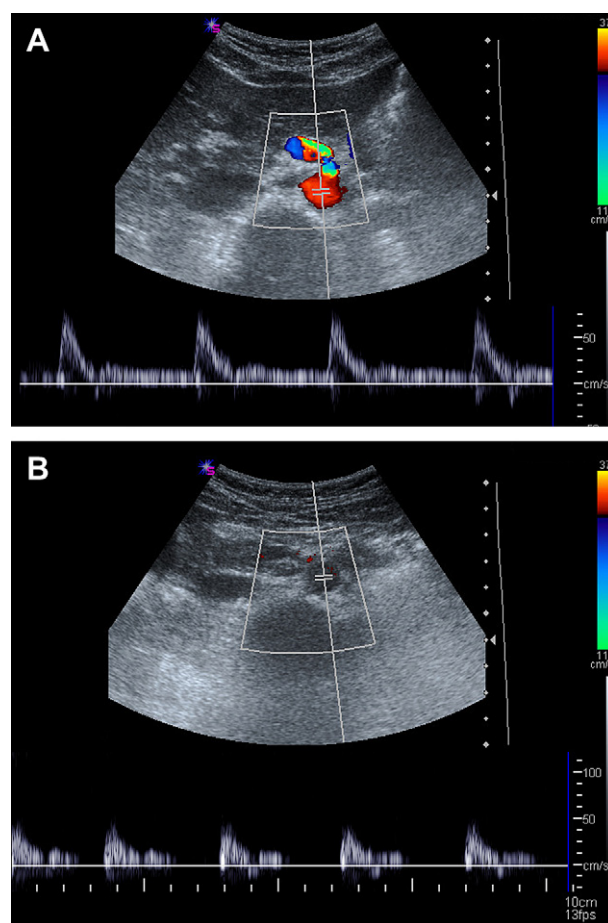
The Doppler waveform of the abdominal aorta varies depending on whether flow is cranially or below the renal arteries: in the former case, there is an appreciable diastolic component, as occurs in areas with low resistance (A); downstream there is no diastolic component, and the trace is characterized by a small inverted wave (districts with high resistance) (B).
